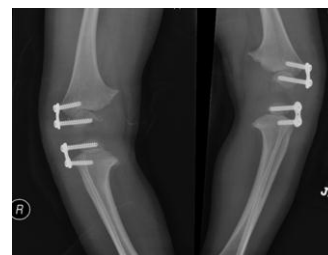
X-ray showing 8-plate hemiepiphysiodesis for bilateral genu varum
